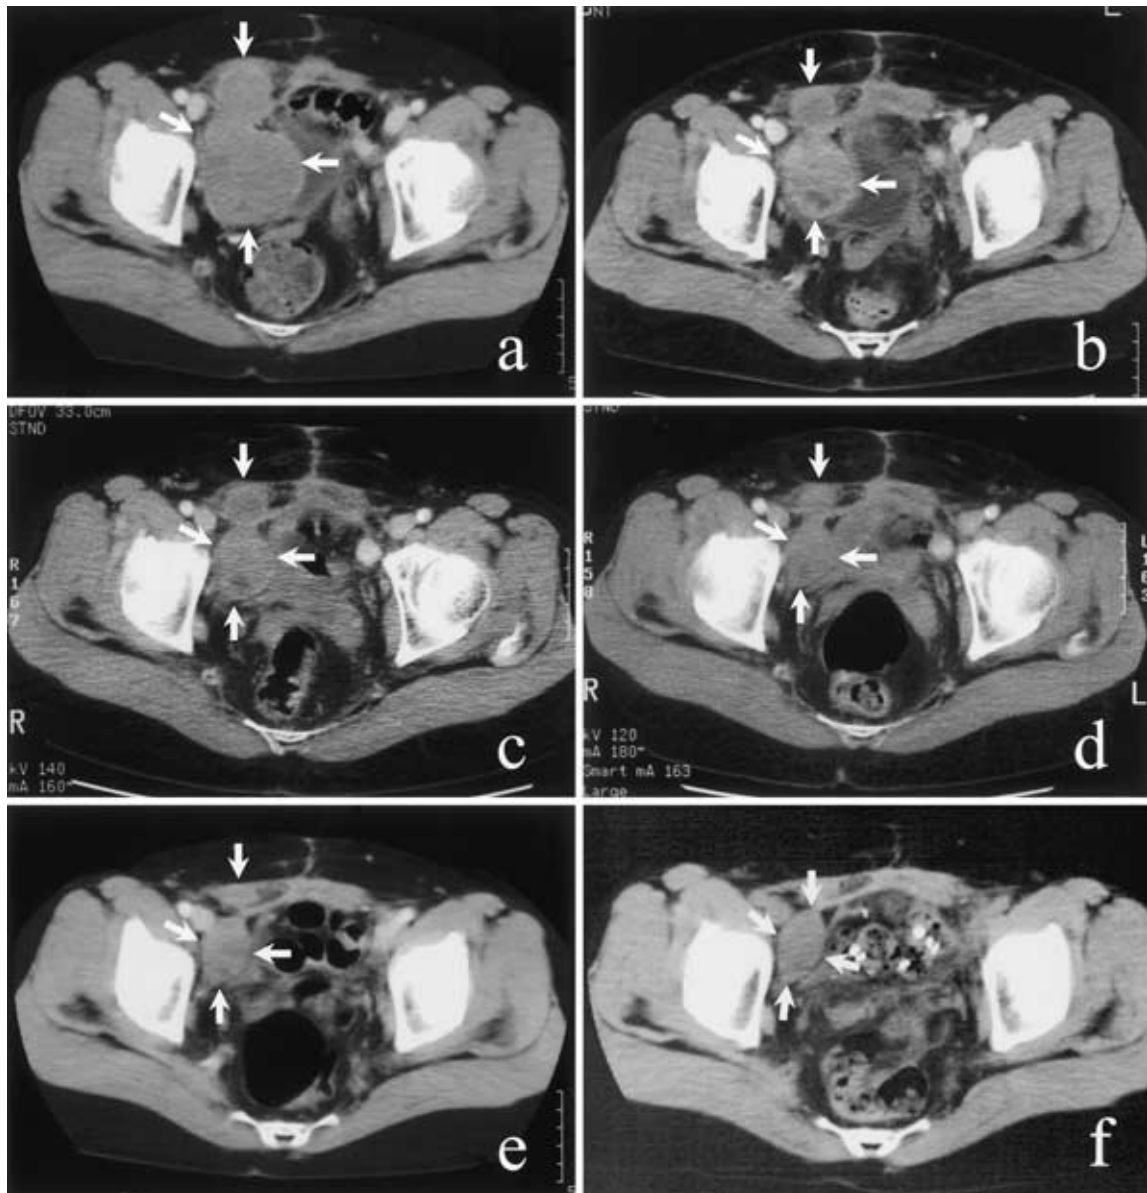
Chronological CT after starting imatinib administration to judge efficacy (tumor is identified by 4 arrows). (a) This massive tumor was in the extrapelvic cavity, although pelvic CT (October 9, 2001) before starting imatinib showed gourd-like tumor broadly occupying the right pelvis. (b) CT in week 3 after starting imatinib administration (January 18, 2002). (c) CT in month 2 after starting imatinib administration (February 19, 2002). (d) CT in month 4 after starting imatinib administration (April 27, 2002). (e) CT in month 6 after starting imatinib administration (June 27, 2002). (f) CT in month 18 after starting imatinib administration (July 10, 2003).
